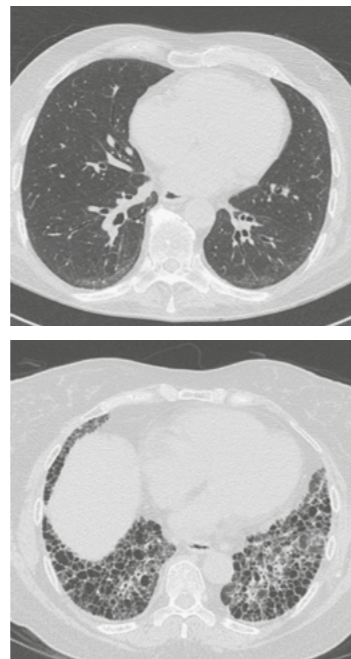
Chest CT in systemic sclerosis. Top panel: Early interstitial lung disease with subpleural reticulations and ground glass opacities in the lower lobes. Patient in supine position. Bottom panel: Extensive lung fibrosis with coarse reticular honeycombing, and traction bronchiectasis. Note dilated esophagus. (Courtesy of Rishi Agrawal, Northwestern University.)
